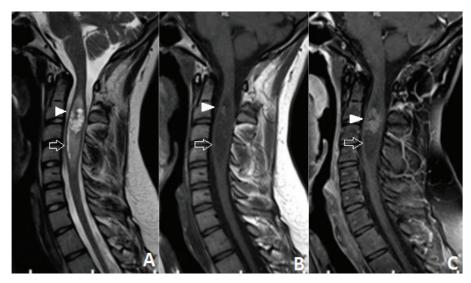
Magnetic Resonance Images of Cervical Spinal Cord Epandymoma
